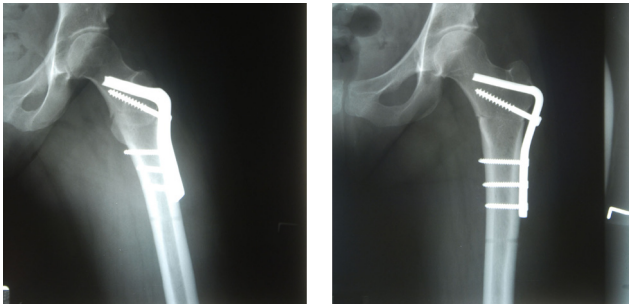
Multiple postoperative radiographs of left hip.
